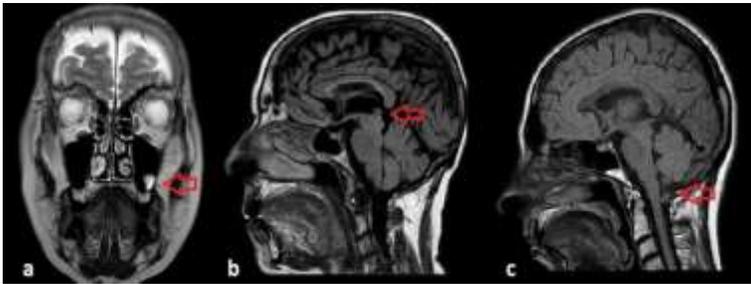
(a) Coronal magnetic resonance image shows left maxillary mucous retention cyst (red arrow), sagittal magnetic resonance images show (b) pineal cyst (red arrow), (c) Chiari malformation 1 (red arrow).
